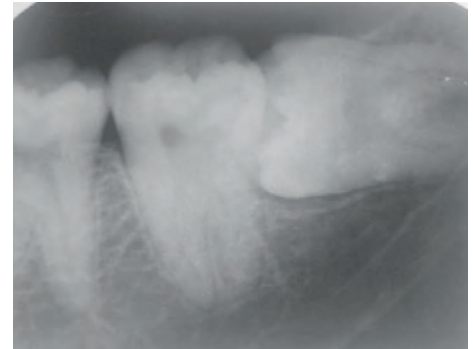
In most cases, the IAN canal is visible on radiographs
